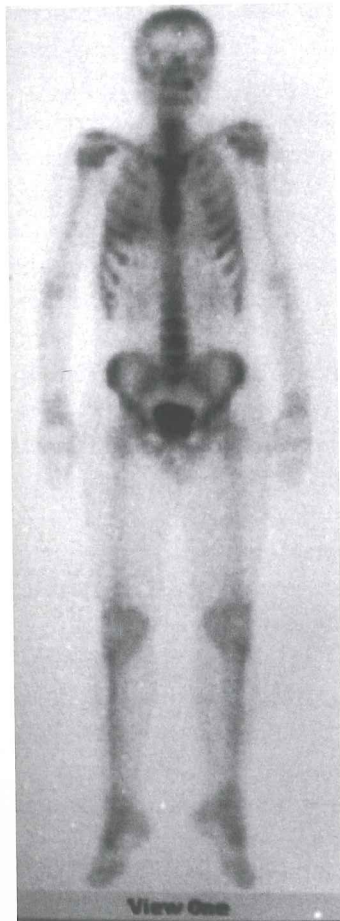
99Tc-MDP lung scintigram of the propositus, posterior view. Diffuse bilateral intensive uptake is demonstrated in both lower lungs.
